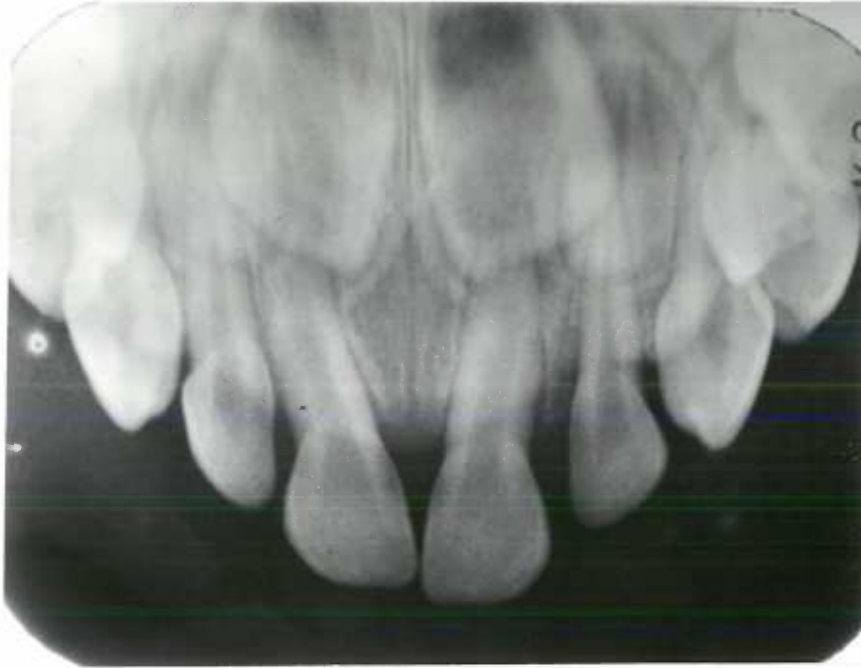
Patient 2. Age three years, radiograph of upper anterior area shows minimal alveolar bone loss.
